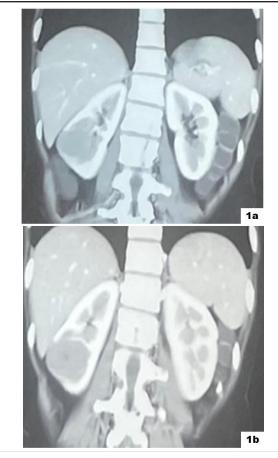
CT shows a renal mass measuring 35x40 mm occupying the mid and lower pole section.
